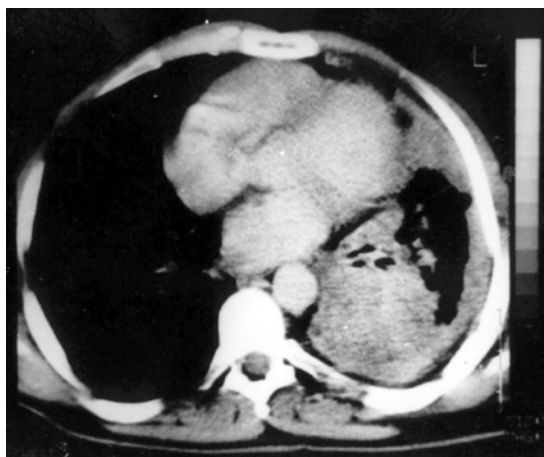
Transverse cut of CT chest of a mesothelioma patient.
